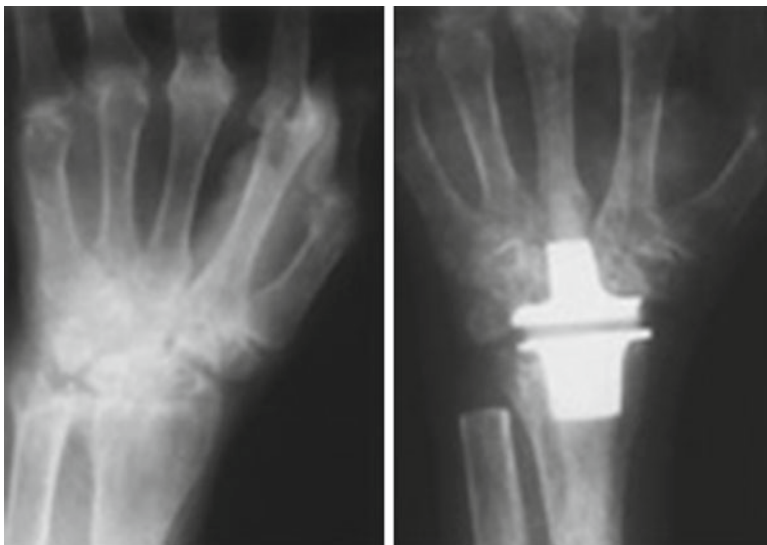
X-ray of a wrist with severe rheumatoid arthritis throughout the wrist before (*left*) and after (*right*) replacement of the wrist joint with an implant [reproduced from Carlson JR, Simmons BP (1998) Total wrist arthroplasty. *J Am Acad Orthop Surg* 6:308–315, for teaching and training]
